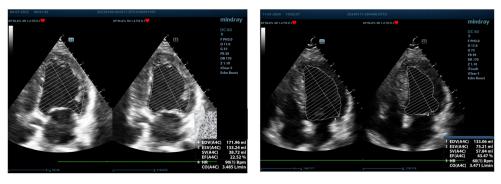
a.10. Evaluation of the LV volumes and LVEF by Simpson method in presented case at first echocardiographyc evaluation (left: EF=22.52%, LVEDV=171 ml) and after 6 months (right: EF=46.47%, LVEDV=133 ml) (2D, 4-chambers view)
